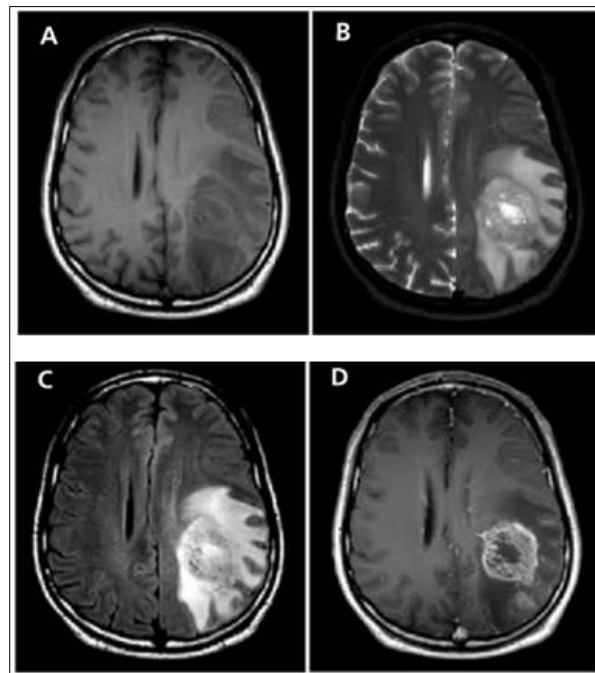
MRI images (A) T1-weighted image, (B) T2-weighted image, (C) FLAIR image, (D) T1C image [42]
